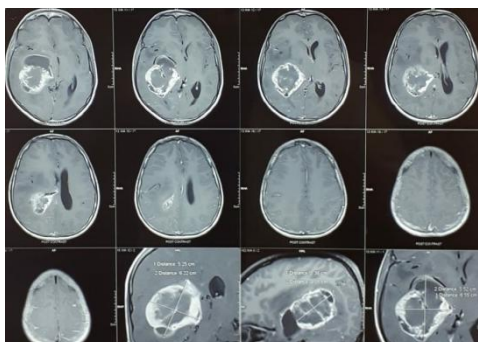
Gliosarcoma preoperative MRI
